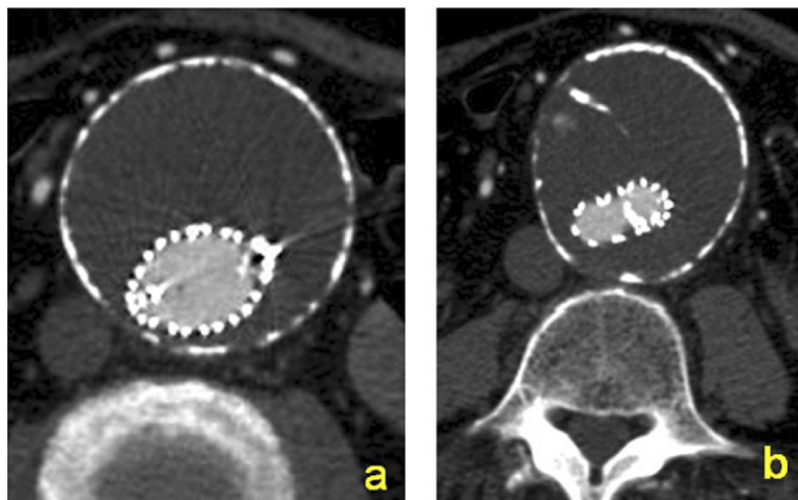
Computed tomographic angiography (CTA) 2 days after occlusion of paraplegia prevention branches (PPBs). a, No flow into the aneurysm at the level of the PPBs. b, No lumbar arteries are perfused from the aneurysmal sac.
